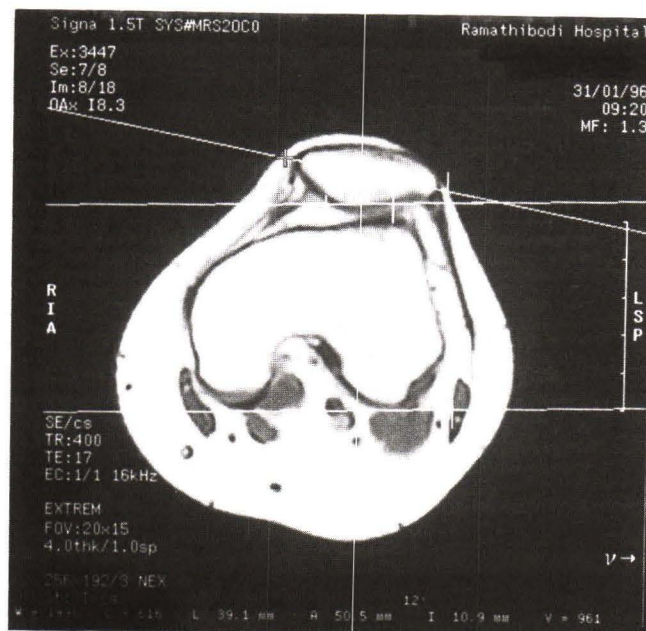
Measurement of patella tilt angle by the MRI machine.
